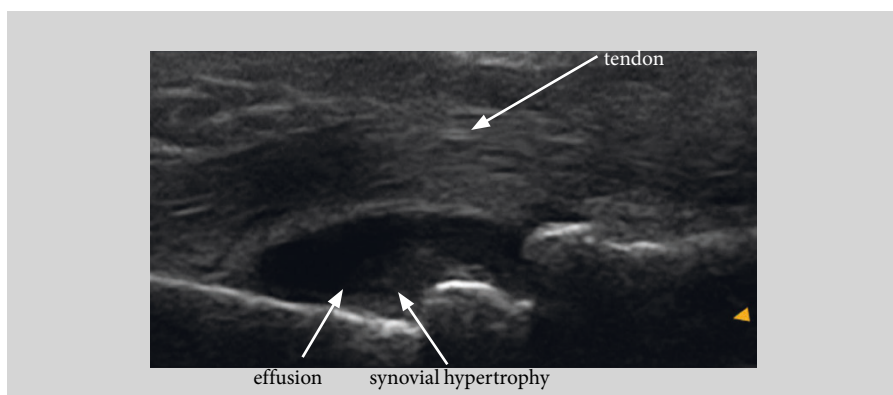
Longitudinal palmar scan of metacarpophalangeal joint: grayscale ultrasound. Presence of effusion (anechoic) and hypoechoic synovial hypertrophy compatible with exudative synovitis.
